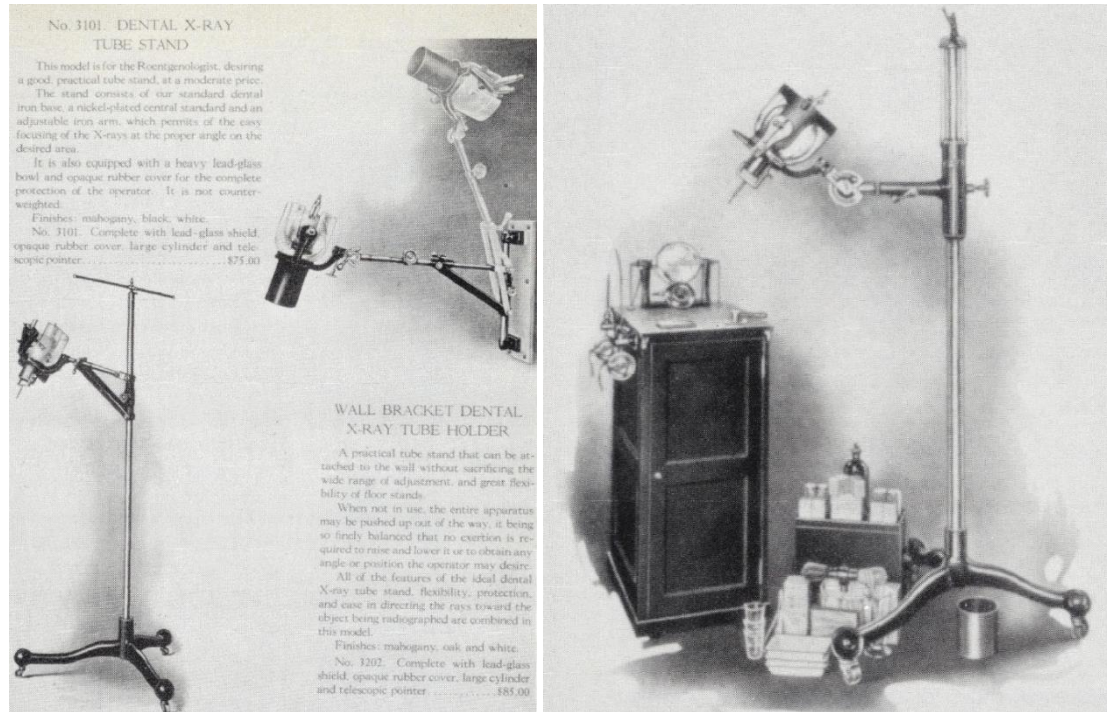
Left: 1917 brochure for X-ray tube stand and wall brackets, used to adapt medical X-ray units for dental radiography. Multi-jointed arms of current intra-oral X-ray tubes were still years removed. Instead, the tube was stationary, and the patient was adjusted accordingly. Right: first commercial X-ray unit in the US (1913), produced by American X-ray Equipment Co. This unit used an induction coil, and was suited for AC or DC input, with exposures times of 10-20 s. The tube was shielded using lead glass [52].
